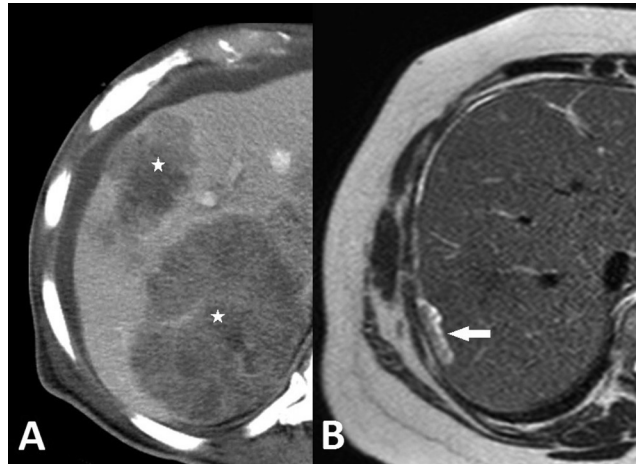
Images showing difference between liver metastases and liver serosal disease. (A) CECT axial image of patient 1 shows sub-capsular liver metastases, which make acute angles of contact with the liver parenchyma. (B) Axial T2 weighted MRI of patient 2 shows infiltrating liver serosal disease which makes obtuse angle of contact with the liver parenchyma.
